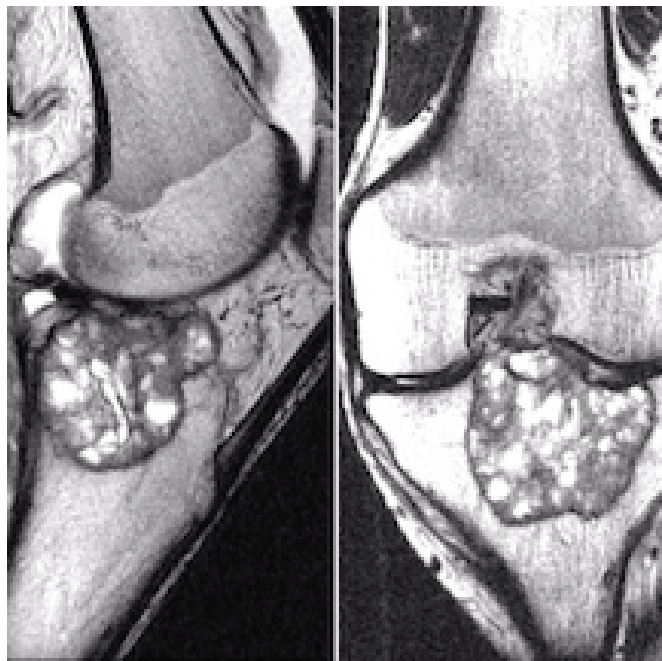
T2 magnetic resonance imaging weighted images, sagittal and coronal showing mixture of intermediate and high signal intensity of lesion.
